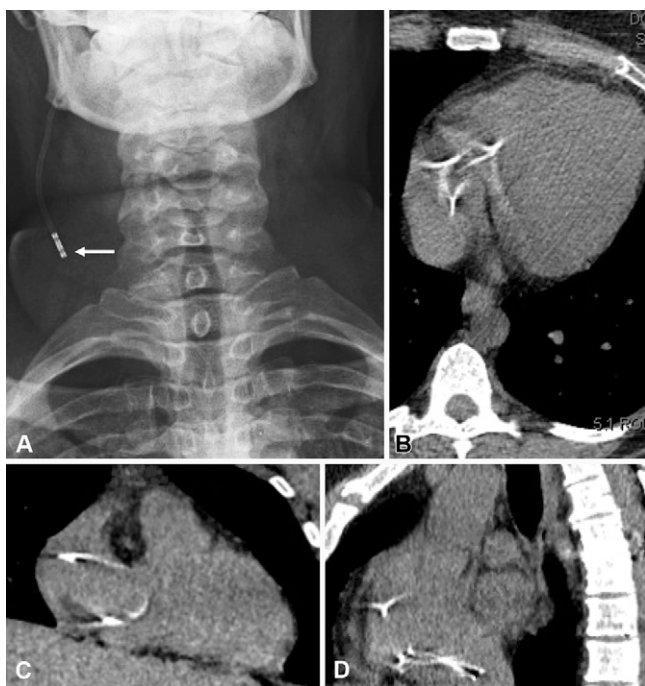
Case 3. Shunt disconnection with distal catheter in right atrium. A: Radiograph demonstrating a disconnection of the distal tubing in the neck at the level of the connector (*white arrow*). B–D: Axial, coronal, and sagittal CTs of the chest demonstrating coiling of the distal catheter within the right atrium.
